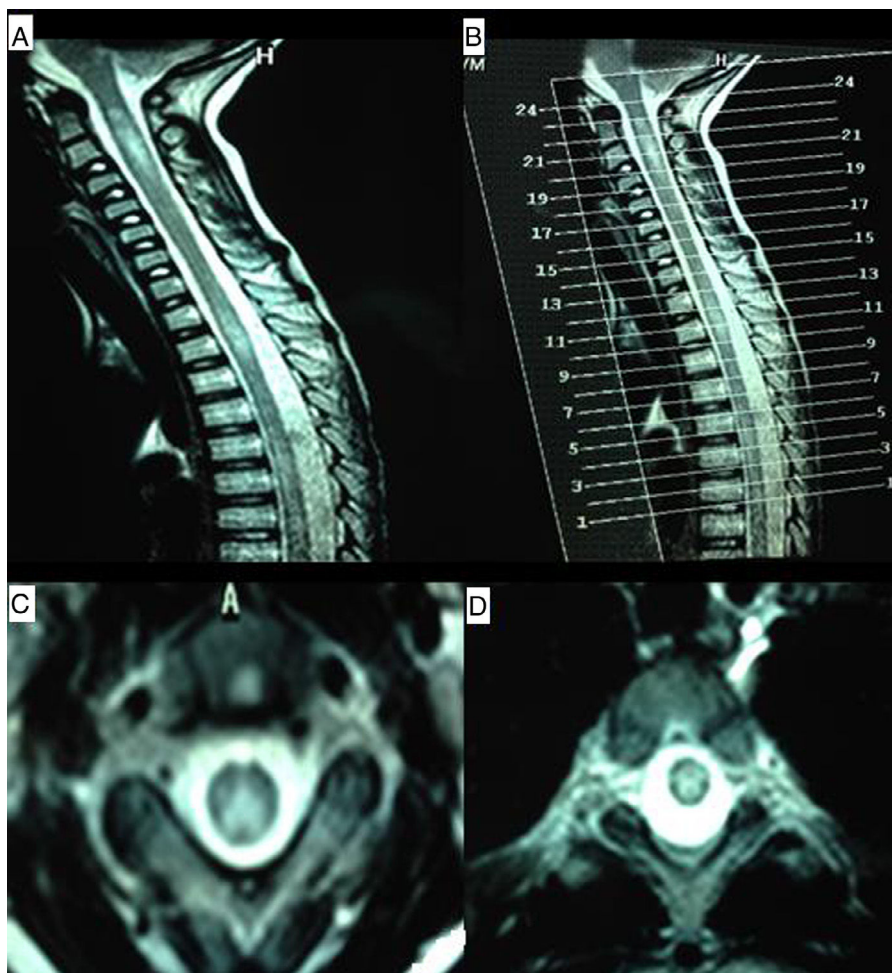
MR images of the cervical and thoracic spine. (A) Sagittal T2-weighted sequence showing hyperintense lesions affecting the C1-C4 and T2-T4 regions. (B) Reference image for axial slices. (C) Axial T2-weighted sequence (slice 21) showing a hyperintense lesion predominantly affecting posterolateral regions of the spinal cord. (D) Axial T2-weighted sequence (slice 11) revealing a centropinal hyperintense lesion.
